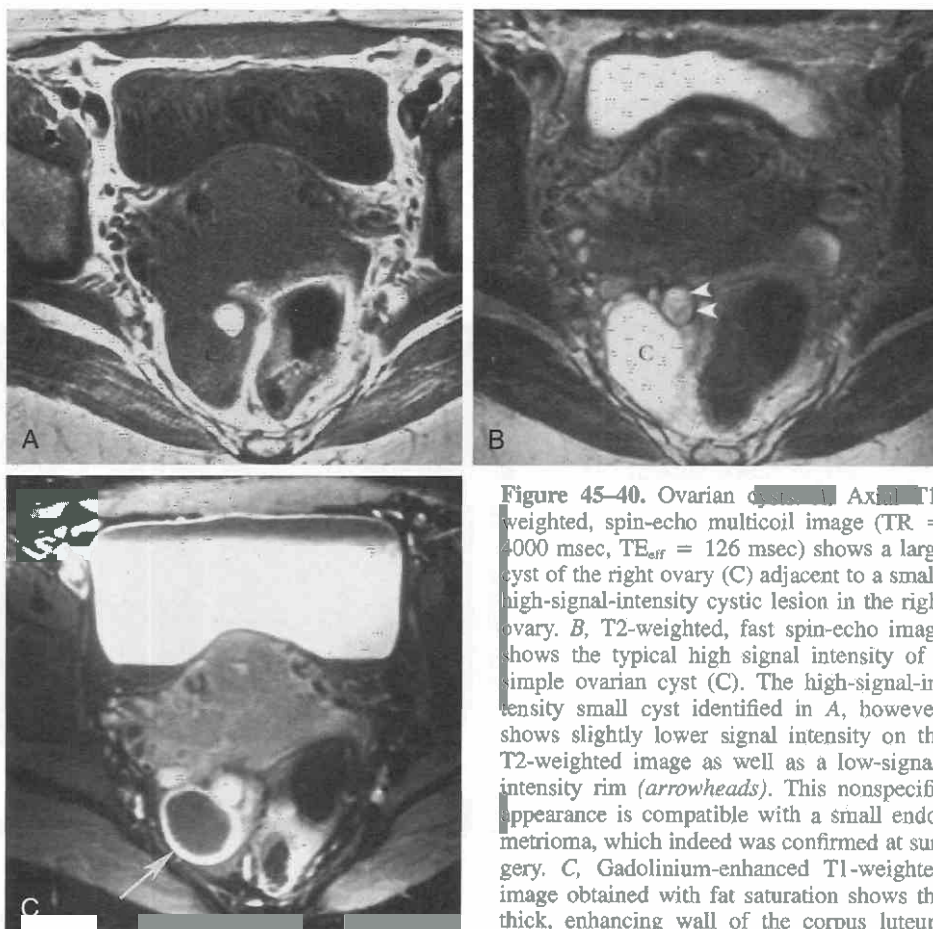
Ovarian cysts. A, Axial T1-weighted, spin-echo multicoll image (TR = 4000 msec, TE_{eff} = 126 msec) shows a large cyst of the right ovary (C) adjacent to a small, high-signal-intensity cystic lesion in the right ovary. B, T2-weighted, fast spin-echo image shows the typical high signal intensity of a simple ovarian cyst (C). The high-signal-intensity small cyst identified in A, however, shows slightly lower signal intensity on the T2-weighted image as well as a low-signal-intensity rim (arrowheads). This nonspecific appearance is compatible with a small endometrioma, which indeed was confirmed at surgery. C, Gadolinium-enhanced T1-weighted image obtained with fat saturation shows the thick, enhancing wall of the corpus luteum cyst (arrow). TE_{eff}, effective echo time.
